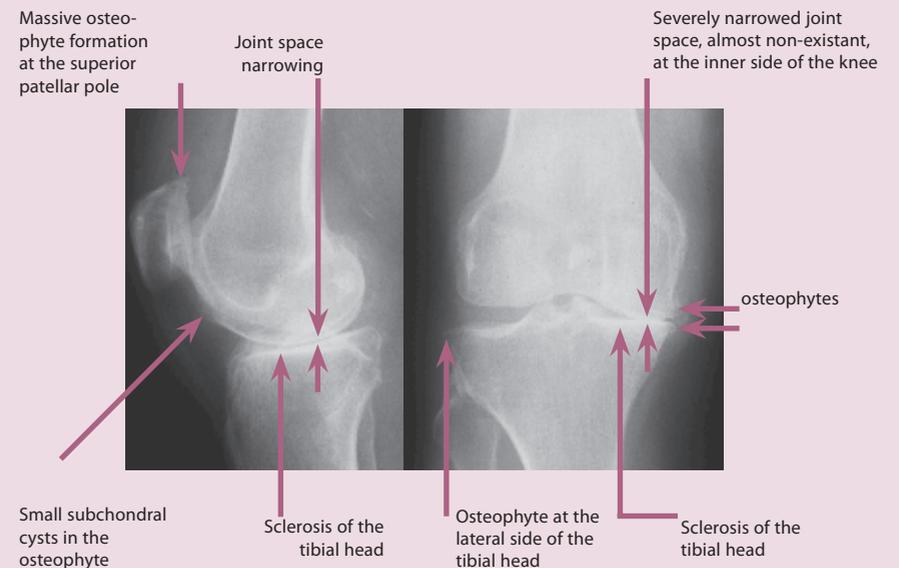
Osteoarthritic knee joint in X-ray images
